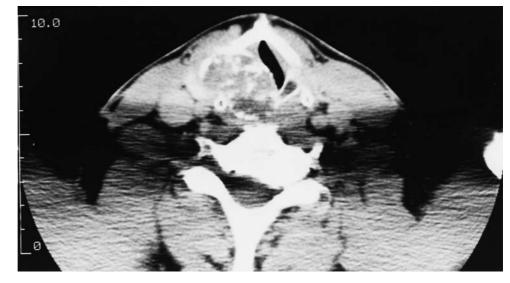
Chondroma of the larynx. Axial computed tomography scan shows a calcified mass arising from the right thyroid cartilage and adjacent cricoid cartilage. The tumor bulges into the airspace and displaces the thyroid cartilage laterally.
